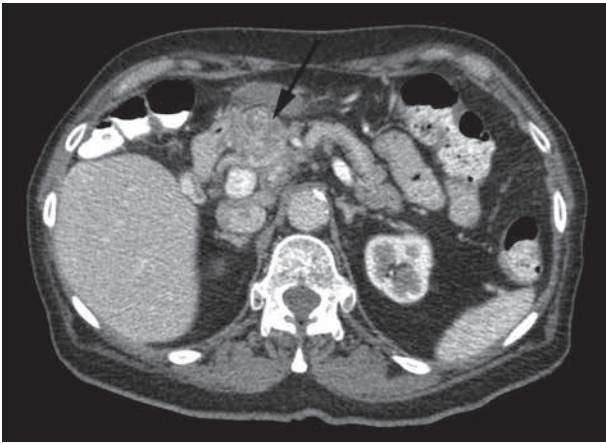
This computed tomography of the abdomen during follow-up of a Merkel cell carcinoma, shows a tumoral enlargement of the head of the pancreas (arrow).
